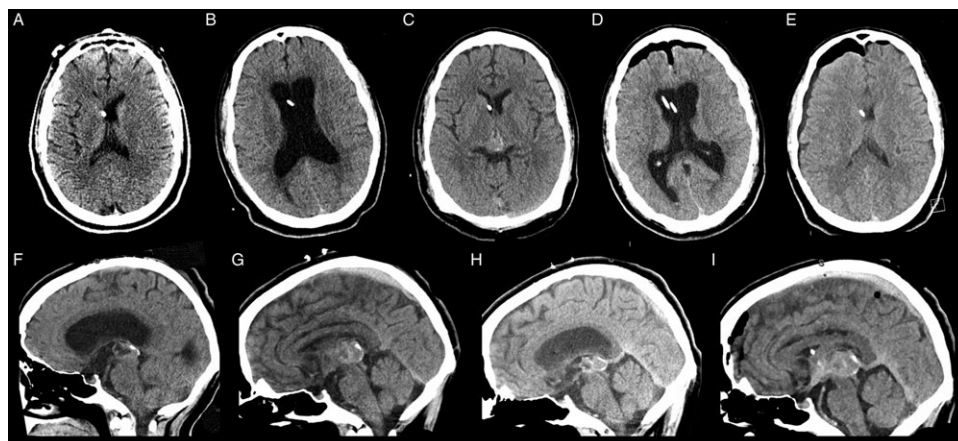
Sequential axial and sagittal brain CT images corresponding to Case 2. (A) shows this patient's baseline, prior to the externalization of his VPS. (B) and (F) show worsening hydrocephalus (day 3). (C) and (G) shows resolved hydrocephalus (day 4), with stretching and displacement of the pineal mass and midbrain toward the supratentorial compartment. (D) and (H) shows interval worsening of hydrocephalus and pneumocephalus (day 6), with compression and displacement of the pineal mass and midbrain toward the infratentorial compartment. (E) and (I) shows slit-like ventricles, subdural hygroma, and persistent pneumocephalus on day 10, with stretching and displacement of the pineal mass and midbrain toward the supratentorial compartment.
